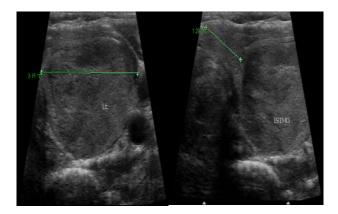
Thyroid ultrasonography: left lobe macronodule with 31.5 mm (left) and peri-isthmus nodule with 12.9 mm (right).
